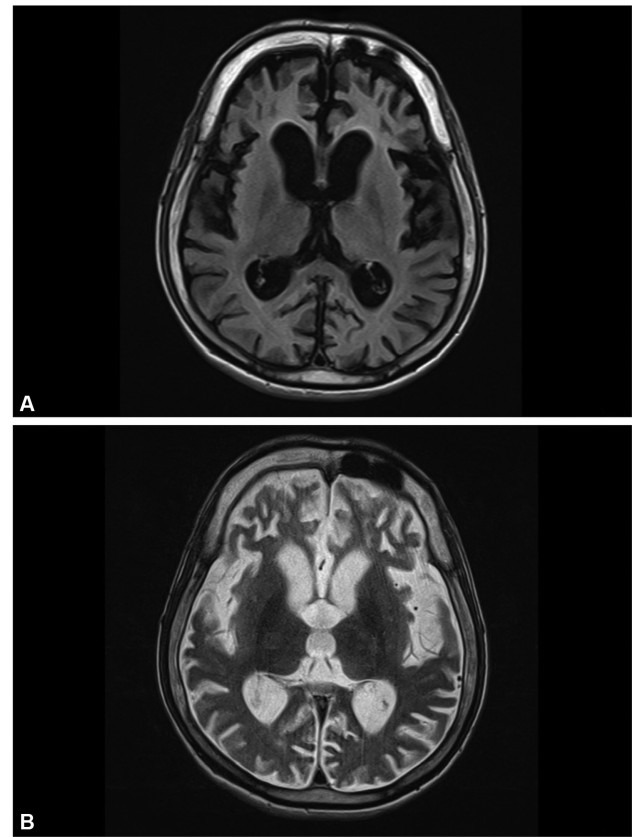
Magnetic resonance imaging (MRI) brain T1- (A) and T2- (B) weighted imaging showing gross cortical atrophy.
